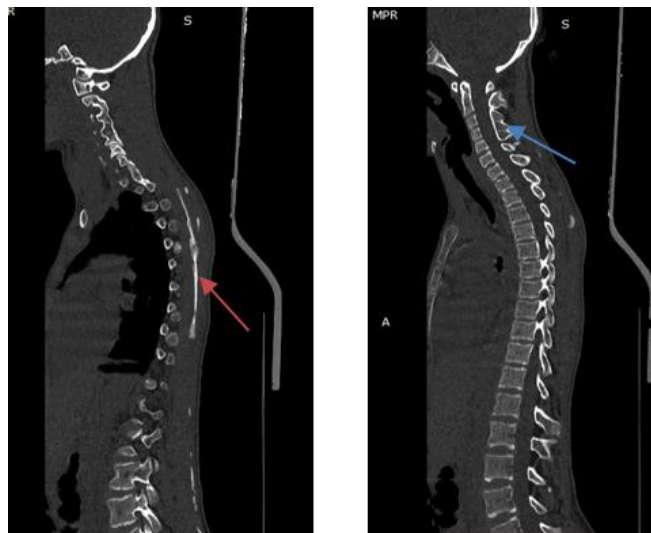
Spinal CT scan (sagittal reconstruction)
